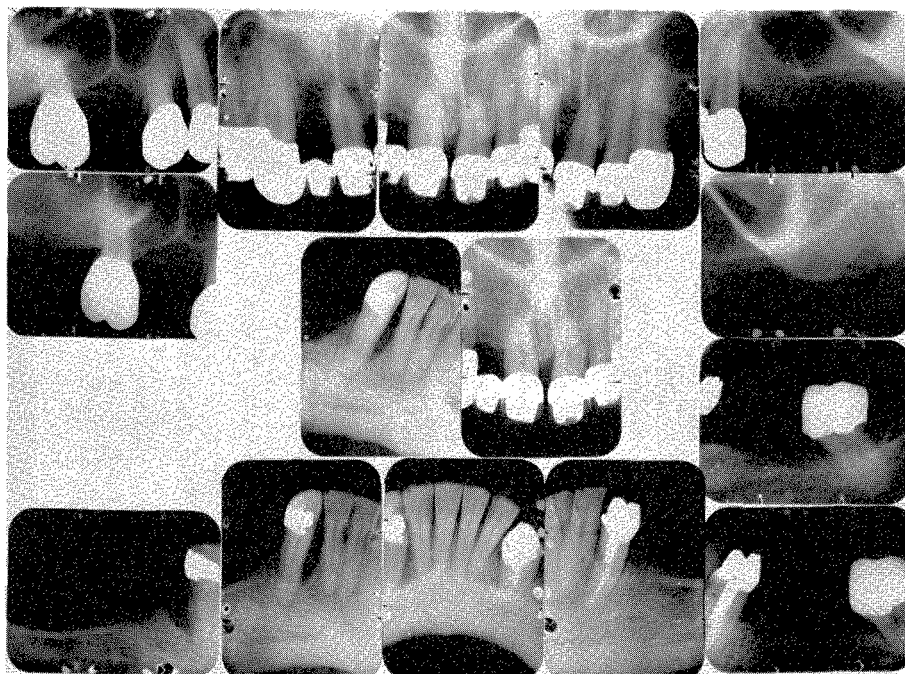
Roentgenograms taken in December, 1949, of the final work.
